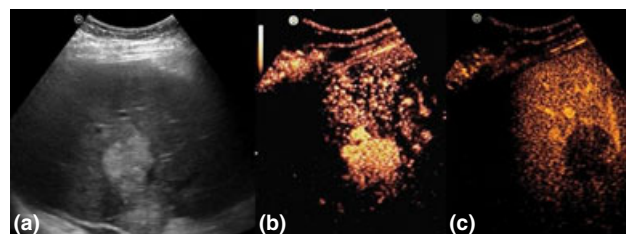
Contrast-enhanced ultrasound of the focal lesion in transplanted liver [B-mode, (a)] with a rapid arterial enhancement within few seconds after injection of 2.5 ml Sonovue[®] contrast (b) and wash-out in the late venous phase at 2 min after contrast injection (c).
